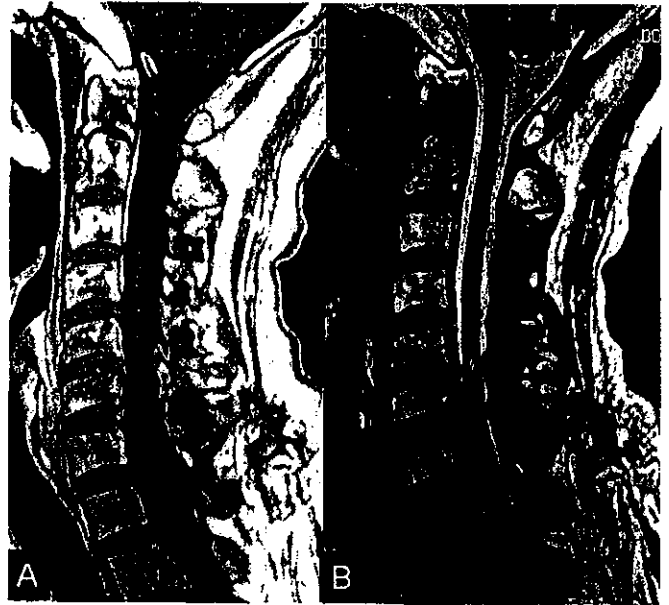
MRI of Patient 1: sagittal T1-weighted imaging (A) and T2-weighted imaging (B) after treatment (2003). Swelling of spinal cord with high intensity on T2-weighted imaging was markedly reduced.
